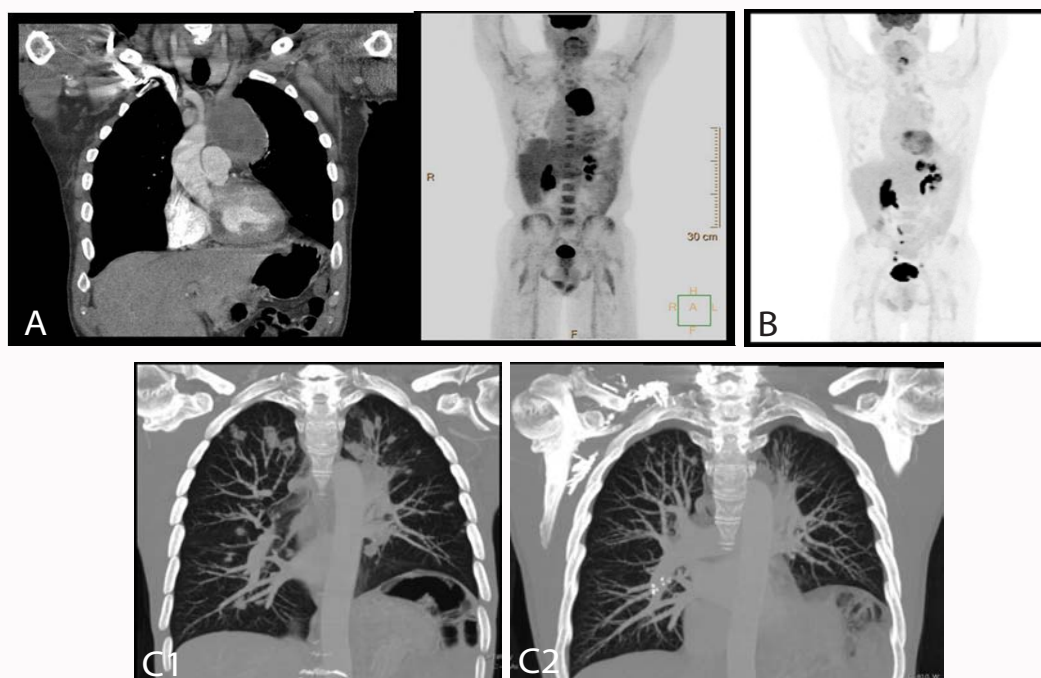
CT and PET images of SW. A: Mediastinal mass at diagnosis. B: Progression to adrenal gland after chemoradiation. C1: Representative lung metastatic lesions prior to starting pembrolizumab. C2: Representative lung metastatic lesions on most recent imaging on pembrolizumab therapy.
